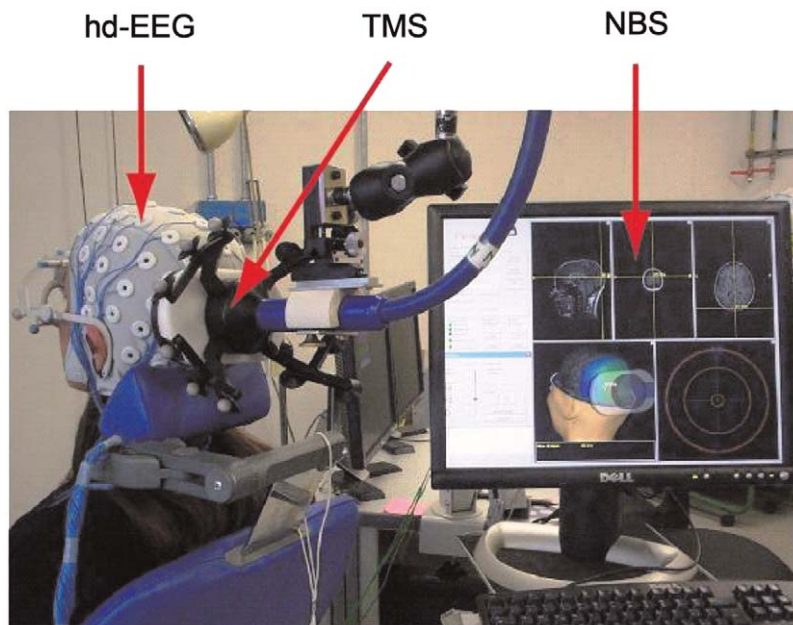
TMS/hd-EEG setup. In this example, a subject is sitting on an ergonomic chair while TMS is targeted to the occipital cortex. The red arrows indicate, from left to right, the three fundamental elements that compose the set-up: (1) a cap for high-density (60 channels) hd-EEG recordings that is connected to a TMS-compatible amplifier; (2) a focal figure-of-eight stimulating coil (TMS), held in place by a mechanical arm; (3) the display of the navigated brain stimulation system (NBS). This system employs an infra-red camera (not visible in this picture) to navigate TMS on a 3D reconstruction of the subject's MRI. The location and the intensity of the electric field induced by TMS are estimated and displayed in real time. To prevent the subject from perceiving the click associated with the coil's discharge, noise masking is played through inserted earplugs. Please see online version of this article for full color figure.
